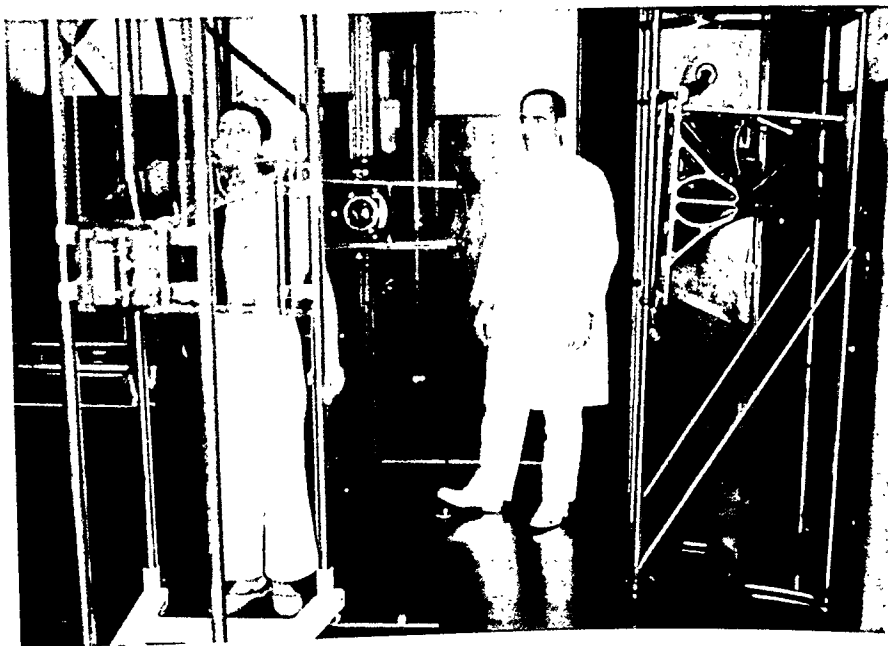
The roentgenphotographic apparatus "Manoel de Abreu" at the Marine Center of Rio de Janeiro (August, 1937).
